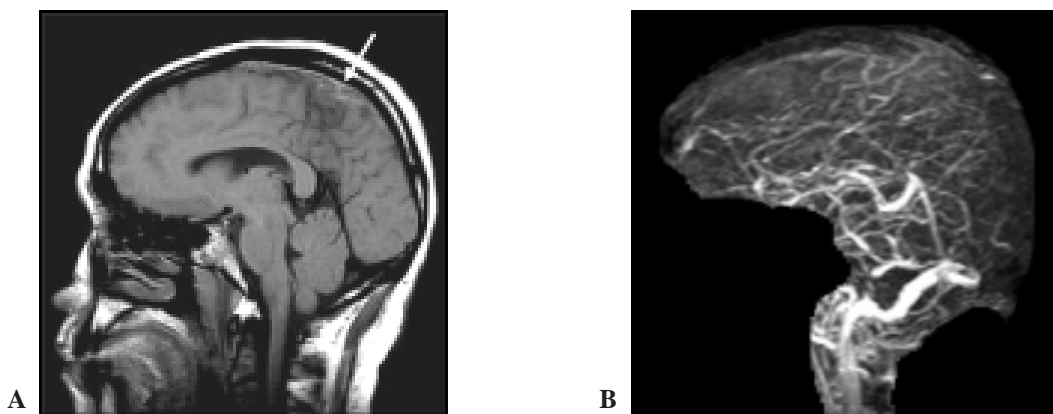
Superior sagittal sinus thrombosis in a 37-year-old female with no underlying disease A. Sagittal T1 weighted MR image shows hypersignal T1-weighted blood clot along the course of the SSS, indicating venous sinus thrombosis (small arrow in A) which is confirmed in 2D TOF MR venography image (B) with non-visualization of the SSS
